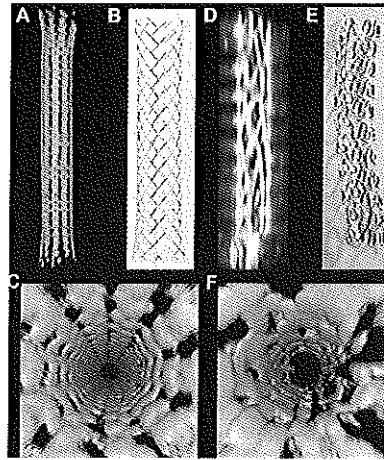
In vitro* intracoronary ultrasound images of (A) and (C) The Wallstent (D) and (F) The Crossflex stent. The three-dimensional (3D) reconstructions of the Wallstent (A) and (B) show a continuous framework of the stent architecture with a blurring effect at the crossings of the stent wires. The 3D reconstructions of the Crossflex stent (D) and (F) show the struts, but the complete stent architecture is discontinuous and is not completely visualized.
